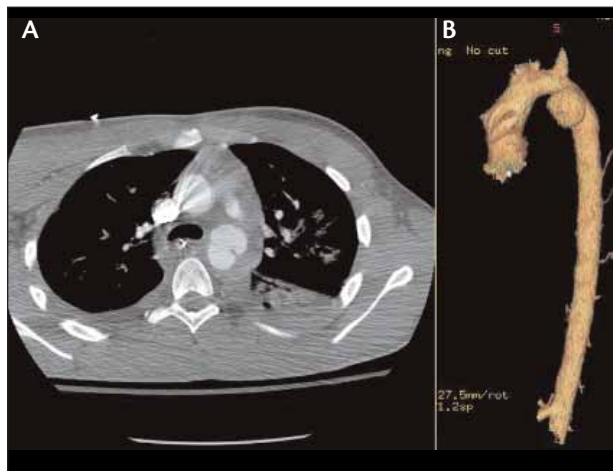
Contrast-enhanced CTA (A) with reconstruction (B) demonstrating BAI with associated pseudoaneurysm, mediastinal hematoma, and left pleural effusion.
